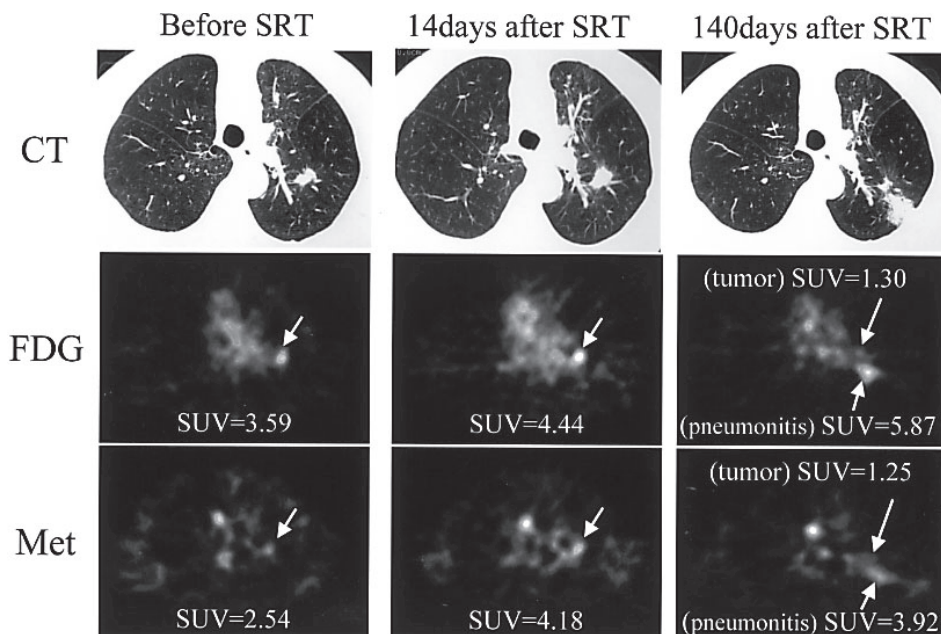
(patient #6). (Left) Before treatment, CT shows a mass lesion (1.5 cm) in the left lower lung (S6). FDG- and Met-PET show high tracer uptake in the tumor. (Middle) Fourteen days after SRT, both FDG- and Met-PET show higher uptake in the tumor than in the pre-treatment study. The corresponding CT shows slight enlargement of the treated tumor. (Right) One hundred and forty days after SRT, the uptake of FDG and Met to the tumor is decreased, while both FDG- and Met-PET show higher uptake in the peripheral lung field. CT shows a decrease in tumor size. Furthermore, CT reveals a new consolidation in the peripheral lung field suggestive of radiation-induced pneumonitis, corresponding to the high uptake of FDG and Met. One year later, follow-up CT showed a decrease in size of this opacity (not shown).
